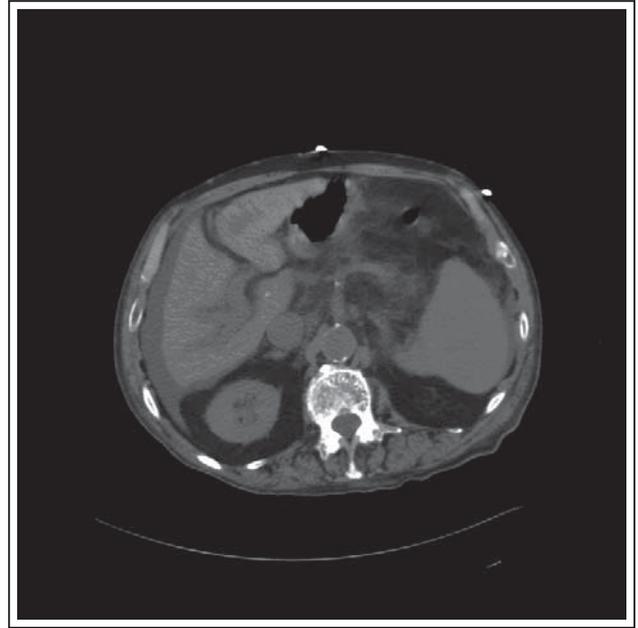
Non-contrast computed tomography scan of the abdomen with signs of portal hypertension including ascites, prominent portal/splenic veins, and splenomegaly.
